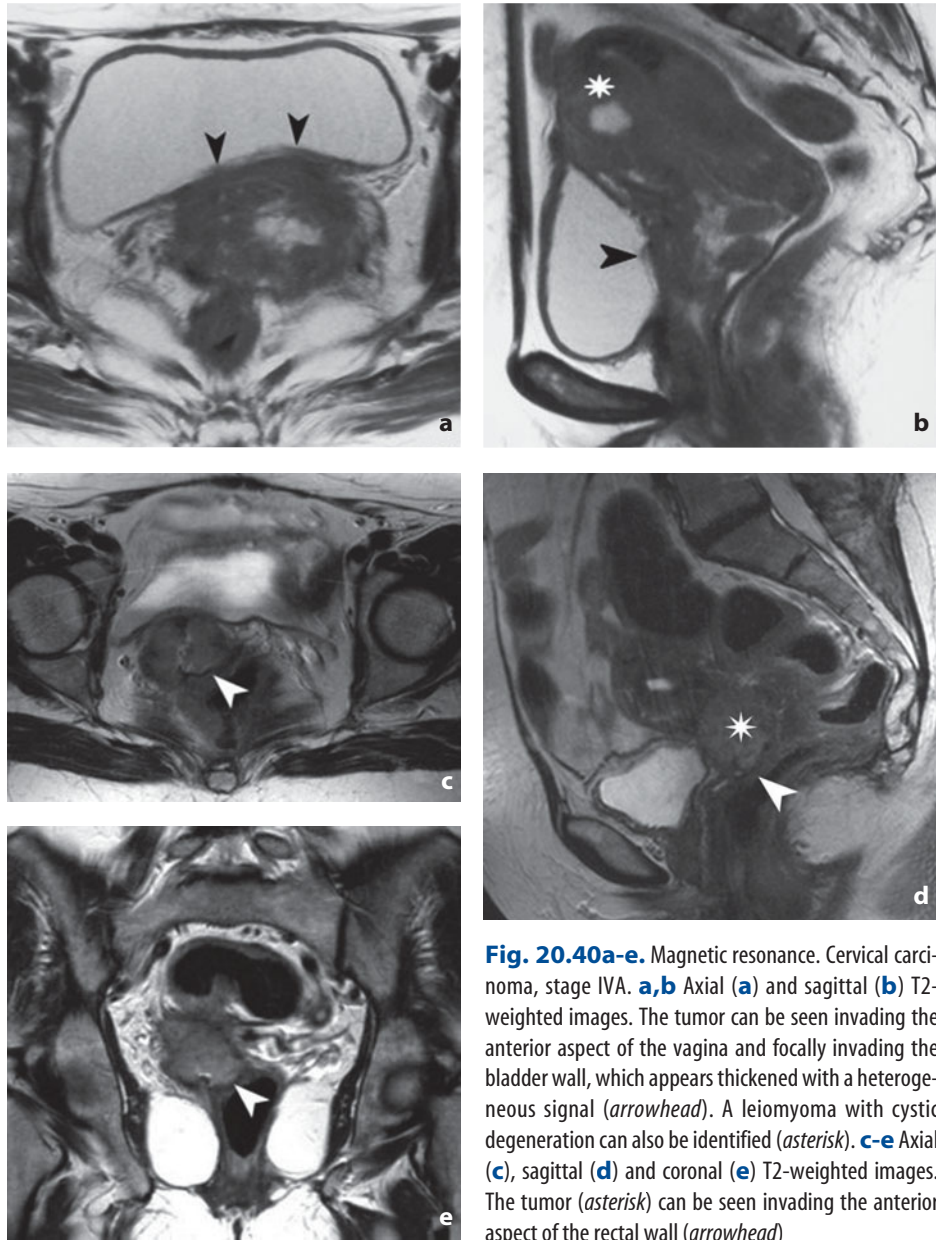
Magnetic resonance. Cervical carcinoma, stage IVA. a,b Axial (a) and sagittal (b) T2-weighted images. The tumor can be seen invading the anterior aspect of the vagina and focally invading the bladder wall, which appears thickened with a heterogeneous signal (*arrowhead*). A leiomyoma with cystic degeneration can also be identified (*asterisk*). c-e Axial (c), sagittal (d) and coronal (e) T2-weighted images. The tumor (*asterisk*) can be seen invading the anterior aspect of the rectal wall (*arrowhead*)
